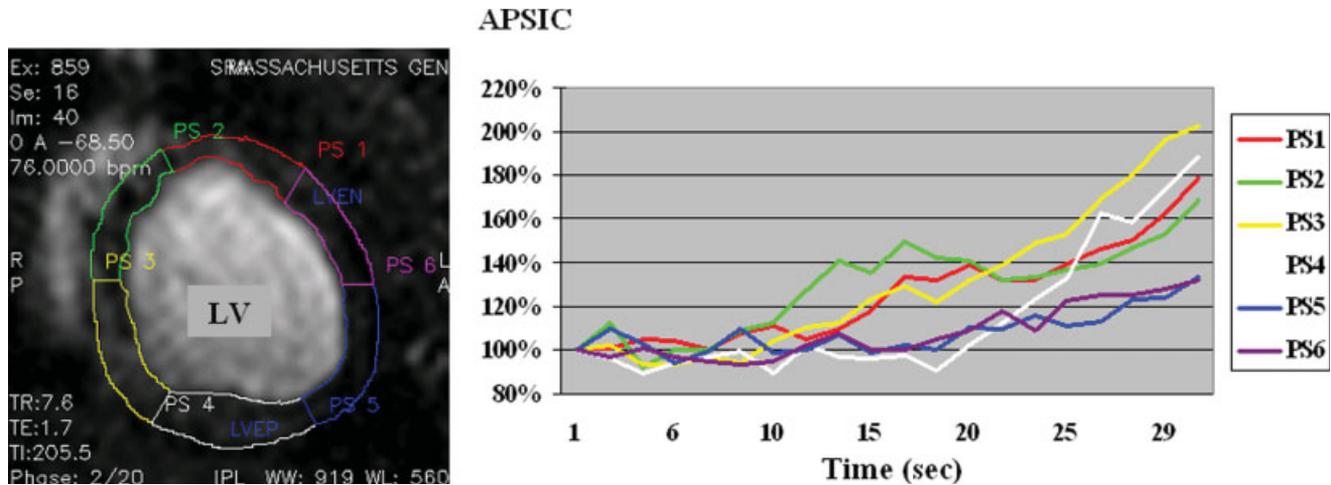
MRI perfusion images 1 month post-VPASS and a graph of the APSIC in each segment. PS1, anterior (red); PS2, anteroseptal (light green); PS3, inferoseptal (yellow); PS4, inferior (white); PS5, inferolateral (blue); PS6, lateral (purple).
